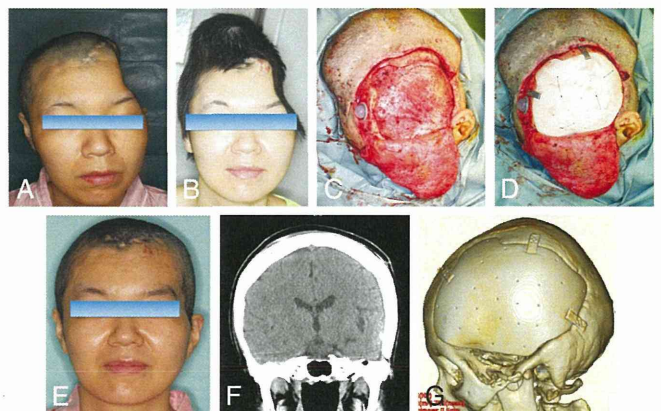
A, A noticeable contour deformity in the skull before cranioplasty. B, Scalp stretching with a tissue expander was performed before cranioplasty. C, After detaching the scalp from the fascia completely, a continuous oozing from the fascia lata was observed. D, Cranioplasty with solid-type artificial bone was performed. E, An aesthetically satisfactory result was obtained after cranioplasty. F, Postoperative CT scan shows symmetry of shape with no low-density areas. G, Postoperative three-dimensional CT scan of the skull and the solid-type artificial bone.
